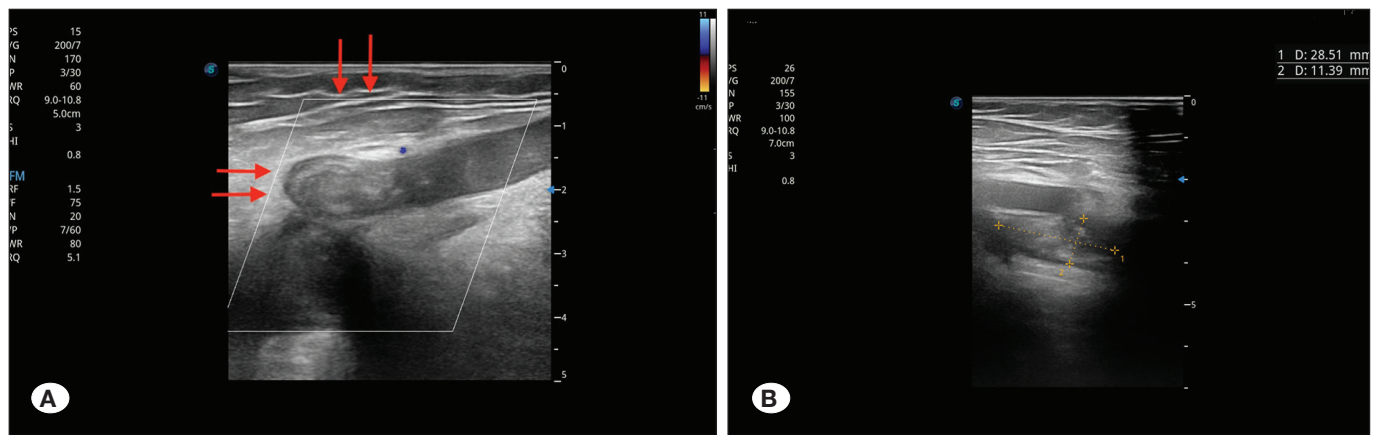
Ultrasound of venous embolism in a 67-year-old female patient. A) Color flow Doppler imaging profile image. B) Ultrasound transverse profile image.
